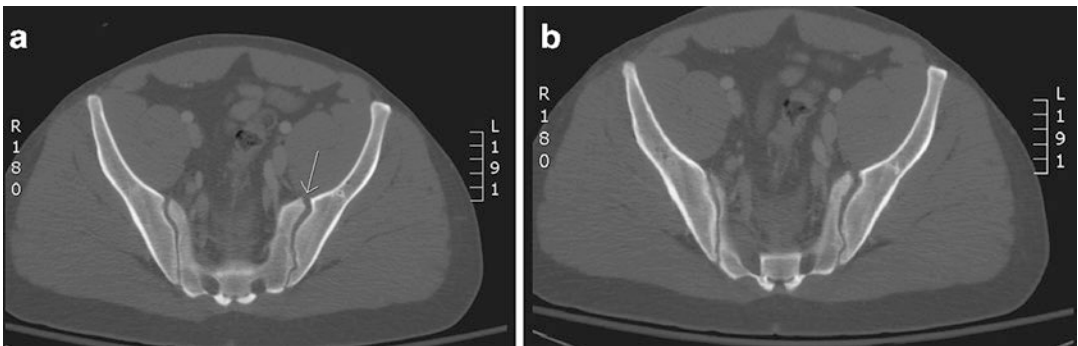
(a, b) Axial CT images of the pelvis are demonstrated
